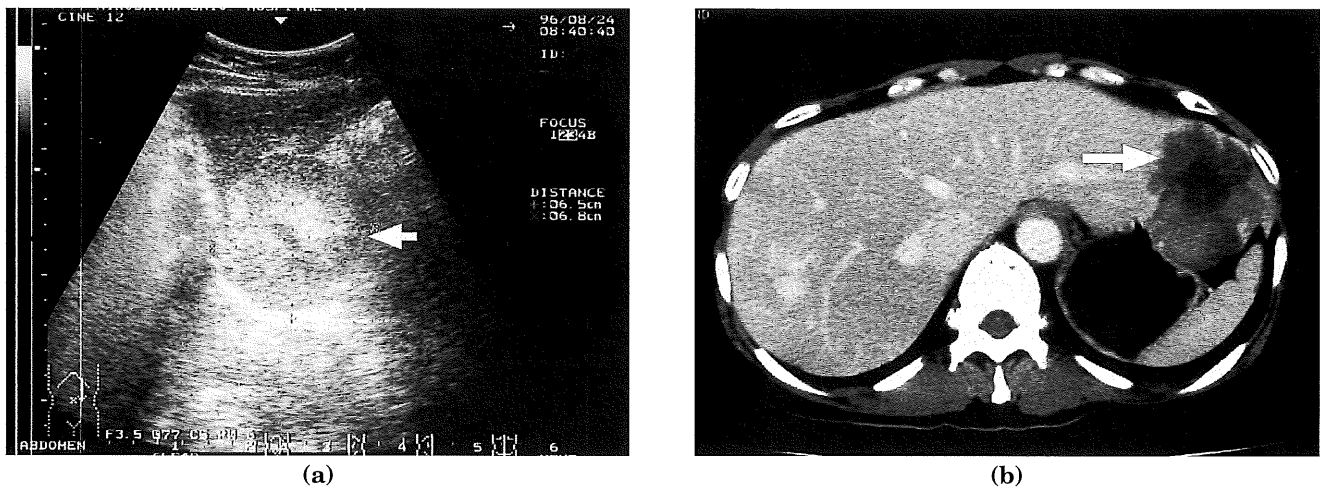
(a) Preoperative abdominal ultrasonogram of case 6, showing a cavernous hemangioma with a mixed echo pattern located at the edge of the left lateral segment of the liver (arrow). (b) CT scan after intravenous injection of contrast material, showing peripheral enhancement of the lesion (arrow).
